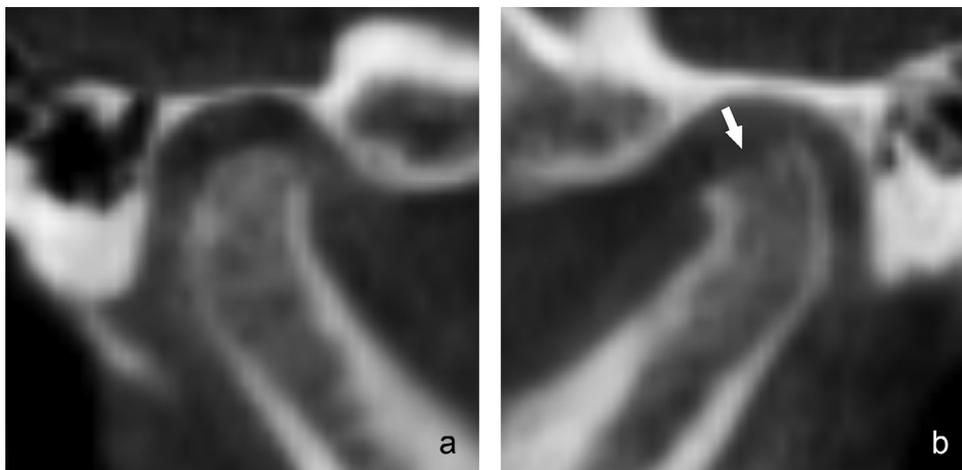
CBCT sagittal cross sections show the right and left TMJs of a patient undergoing unilateral active degenerative joint disease. (a) The right side is normal. (b) The left side shows decortication and erosion of the articular surface (arrow).
